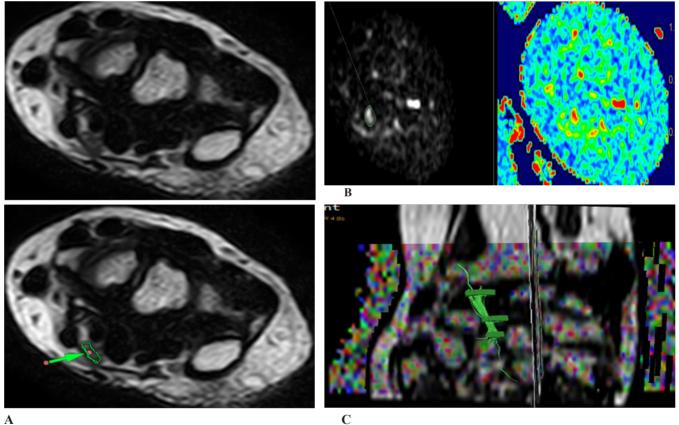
A 65-year-old female with left hand pain, and paresthesia. The NCS showed left moderate CTS. MRI examination showed: A: T2 axial weighted images revealed increased T2 signal, increased CS diameter, bowing of capsule, thickening at the inlet, flattening at the outlet, and mild surrounding edema. B: DWI and DTI revealed a left MN (CSA) of 26.5mm2 at the pisiform level and 21.8mm2 at the hook of Hamate. C: MRN revealed FA: 0.401± 0.165 and ADC: 1.057± 0.362.
